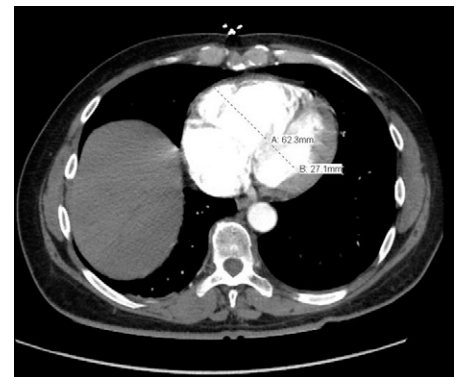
Evidence of right ventricular dysfunction on a computed tomographic angiogram with a right ventricle (A)/left ventricle (B) ratio greater than 1 (62.33 mm/27.1 mm = 2.29).
